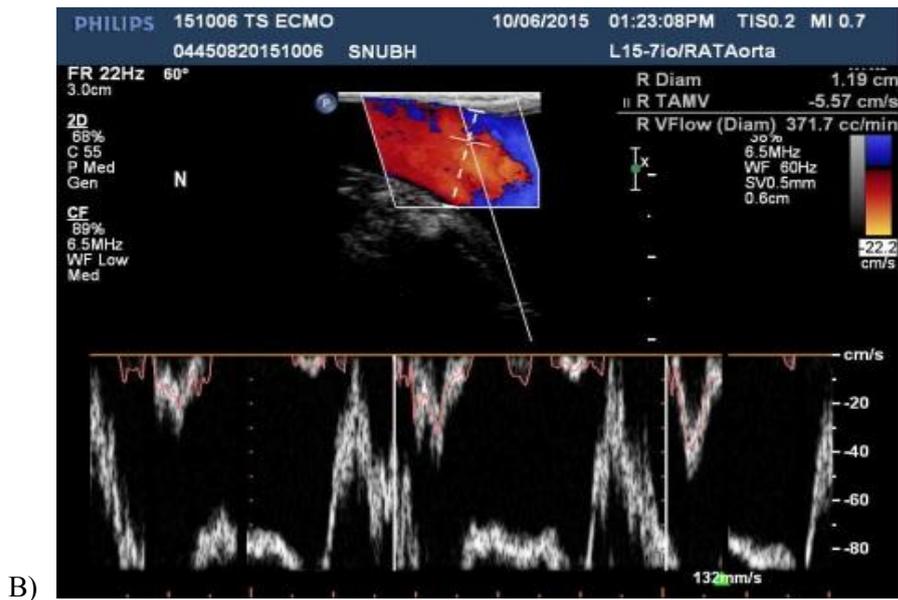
LSCA blood flow check with doppler.
